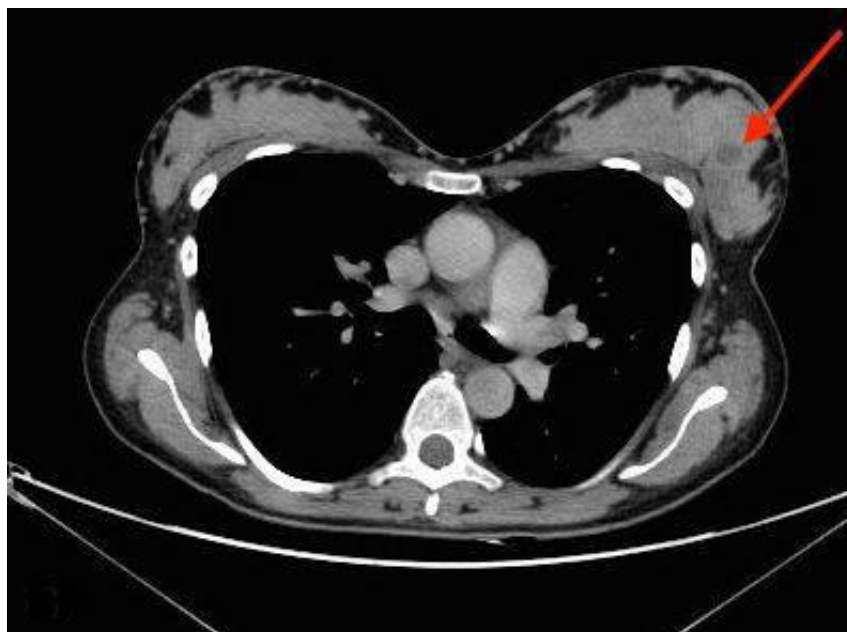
On CT scan, a left breast mass with liquid density areas were visible
